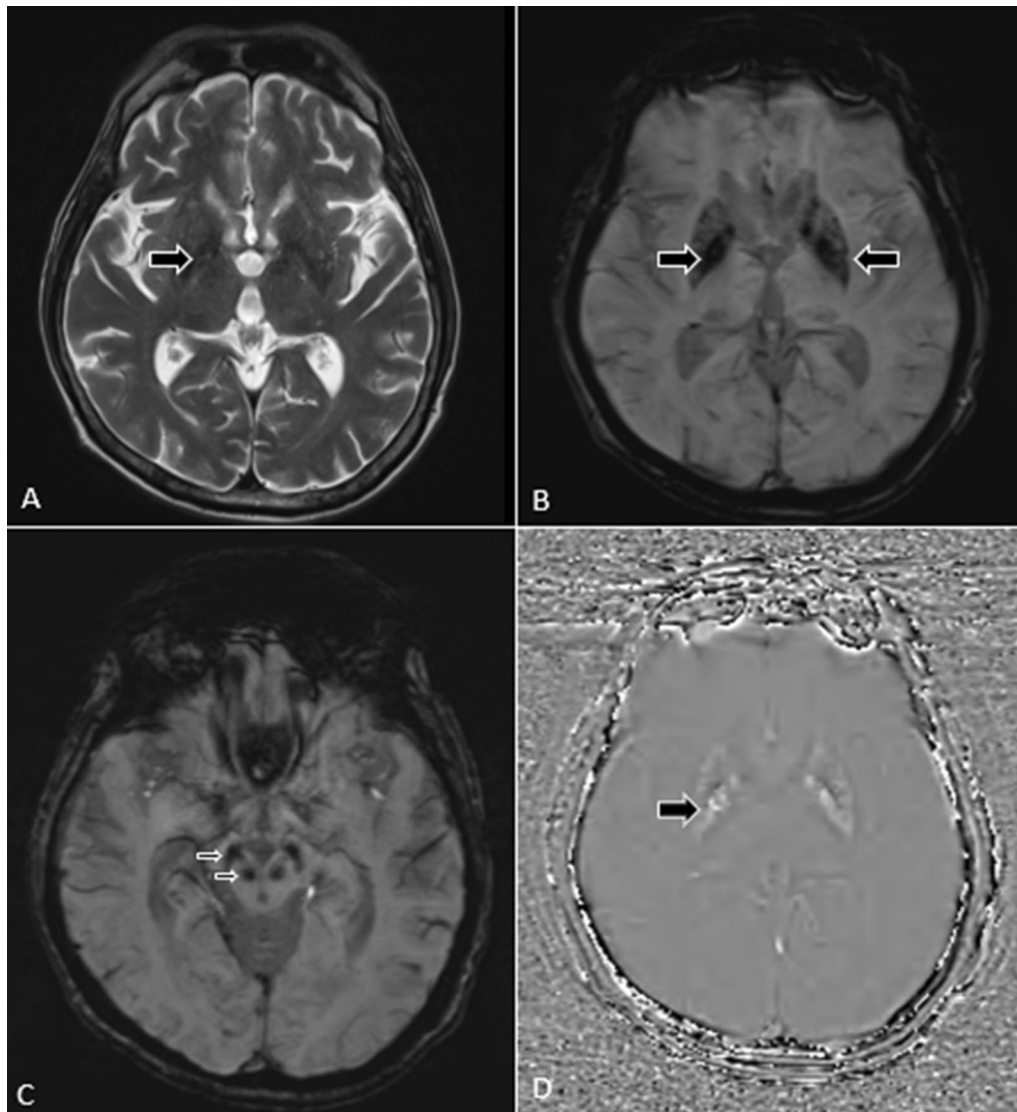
Magnetic resonance imaging of brain reveals hypointense signals in basal ganglia on T2-weighted image (A). Susceptibility-weighted imaging reveals areas of signal dropouts in bilateral basal ganglia (B), substantia nigra and red nuclei (C) with bright signals in basal ganglia in filtered phase image (D). These findings are consistent with mineral deposition
